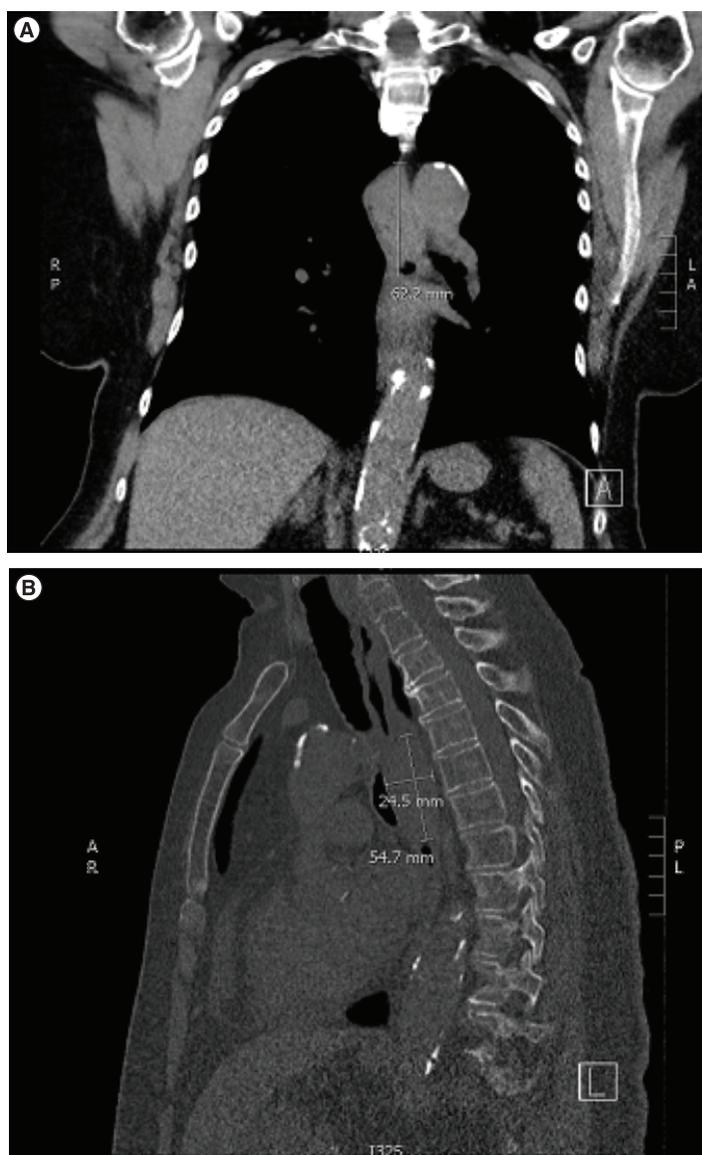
Computed tomography images of esophageal mass. (A) Coronal images of thorax. (B) Sagittal images of thorax. Arrows indicate esophageal mass. Measure bars recorded in ml.
